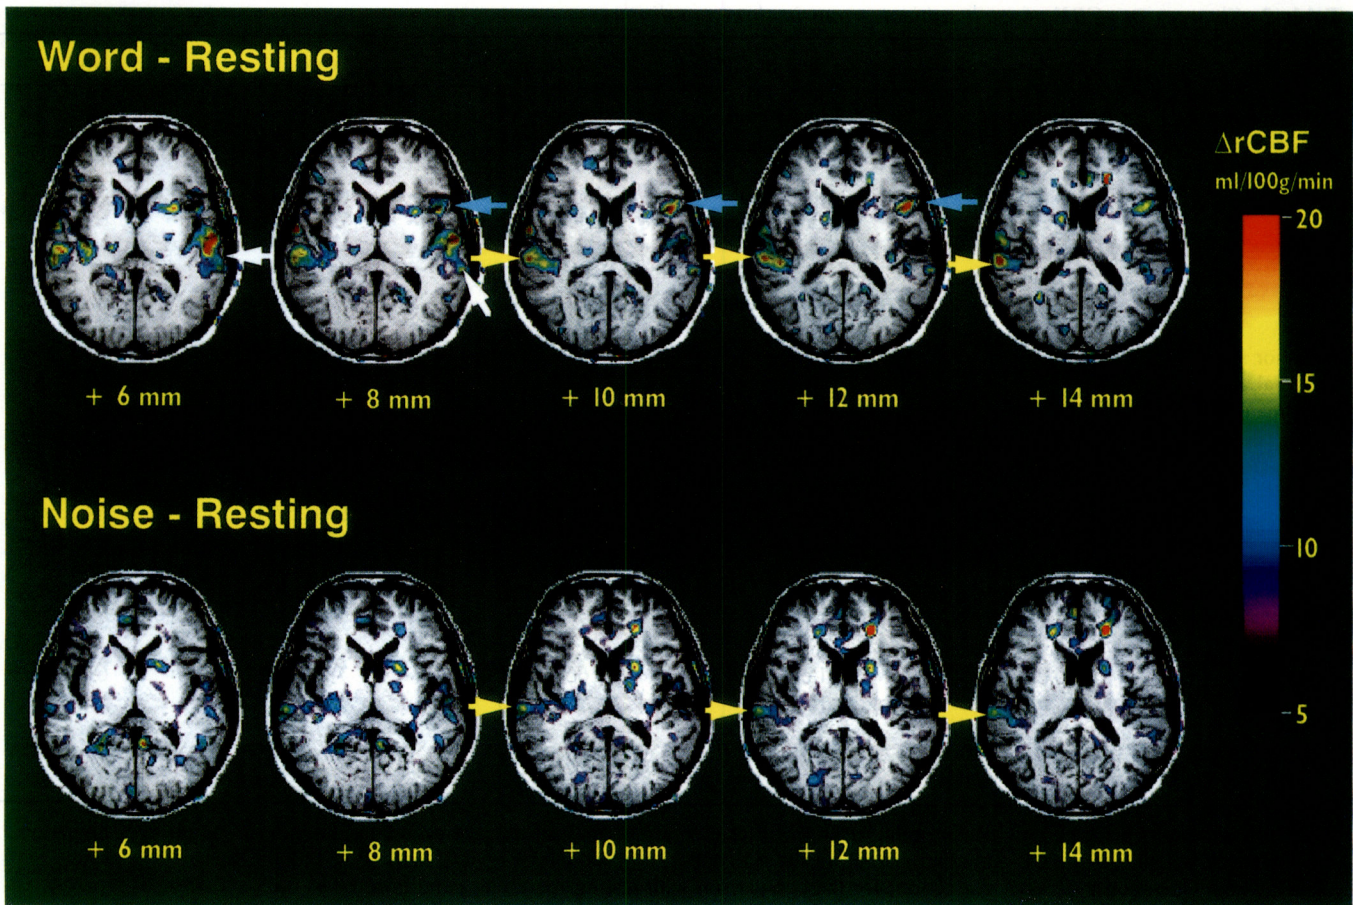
Subtracted PET images of Subject 1 superimposed on her MRI in axial sections. She is postlingually deaf and had CI surgery on the left side. Co-registration of PET and MRI clearly shows the activated foci in the primary auditory cortex contralateral to the CI side (yellow arrows), Wernicke's area (white arrows), and Broca's area (blue arrows) in the left cerebral hemisphere during verbal stimulation (top). During noise stimulation, only the primary auditory cortex was intensely activated (bottom). The scale is the value of rCBF change after global normalization. The number at each slice level is the distance (in millimetres) from the AC-PC plane.
